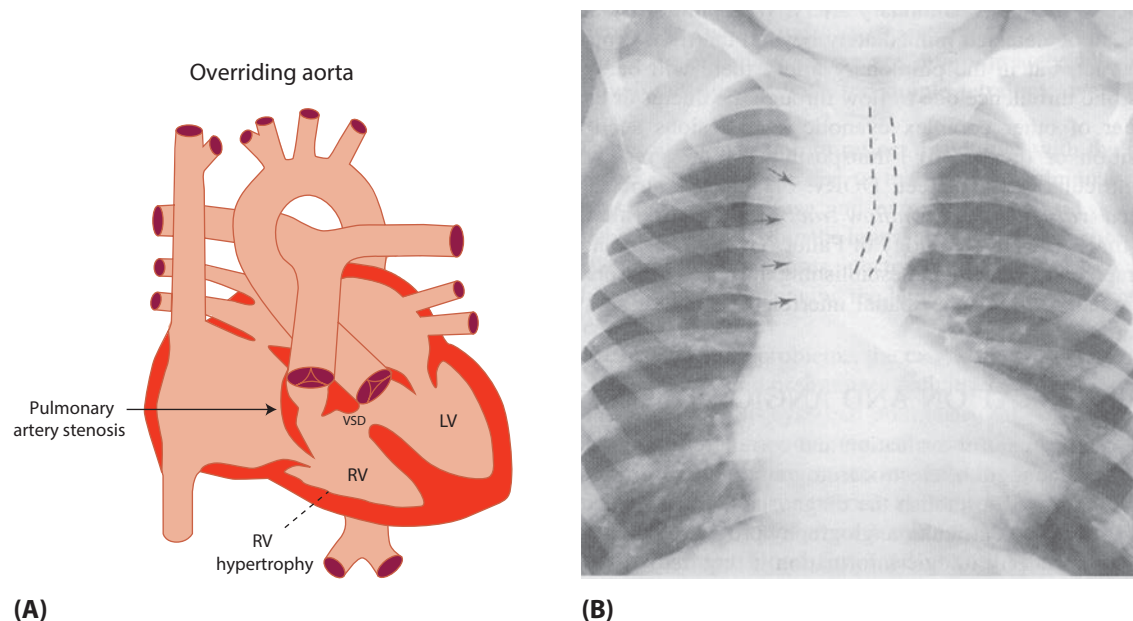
Chest x-ray in tetralogy of Fallot. Arrows indicate right-sided aortic arch and upper thoracic aorta. Dashed lines indicate right-sided aortic indentation on the air bronchogram. (X-ray reproduced, with permission, from Rudolph CD, et al (eds). *Rudolph's Pediatrics*, 21st ed. New York: McGraw-Hill, 2002: 1821.)
